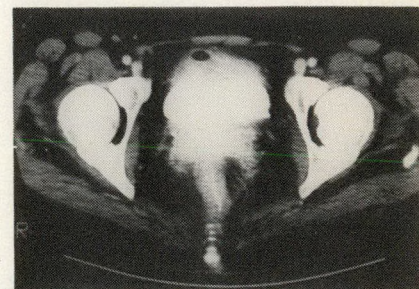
Computed tomogram of pelvis revealing air in bladder with intravenous contrast.
